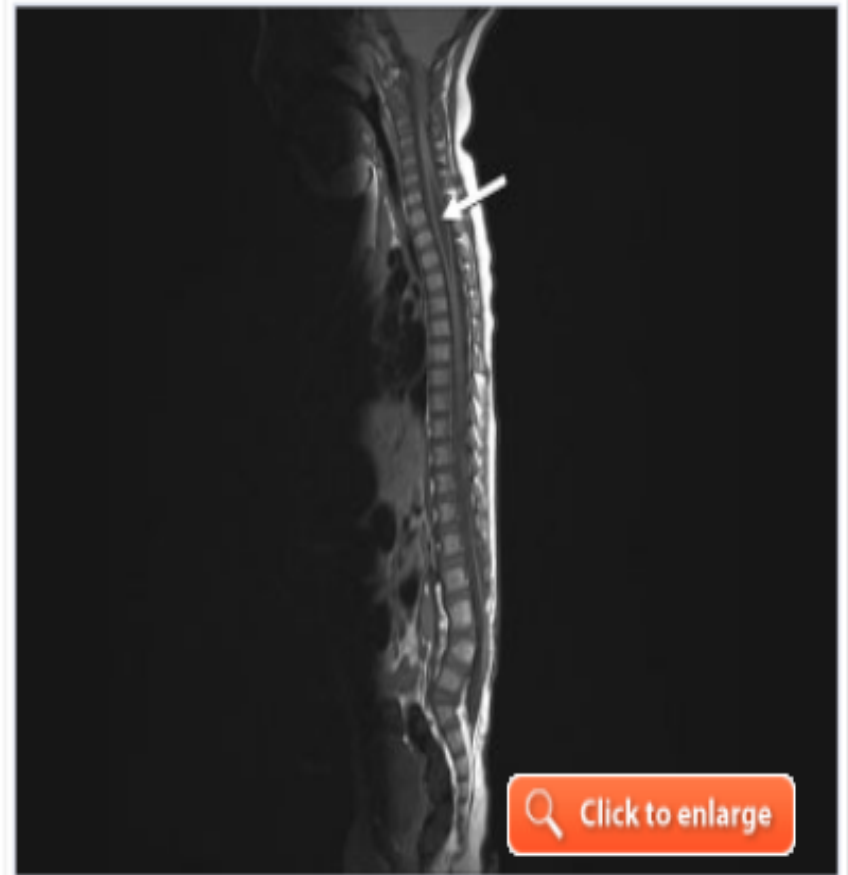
MRI showing an ACM II and a cervicothoracic syrinx.
